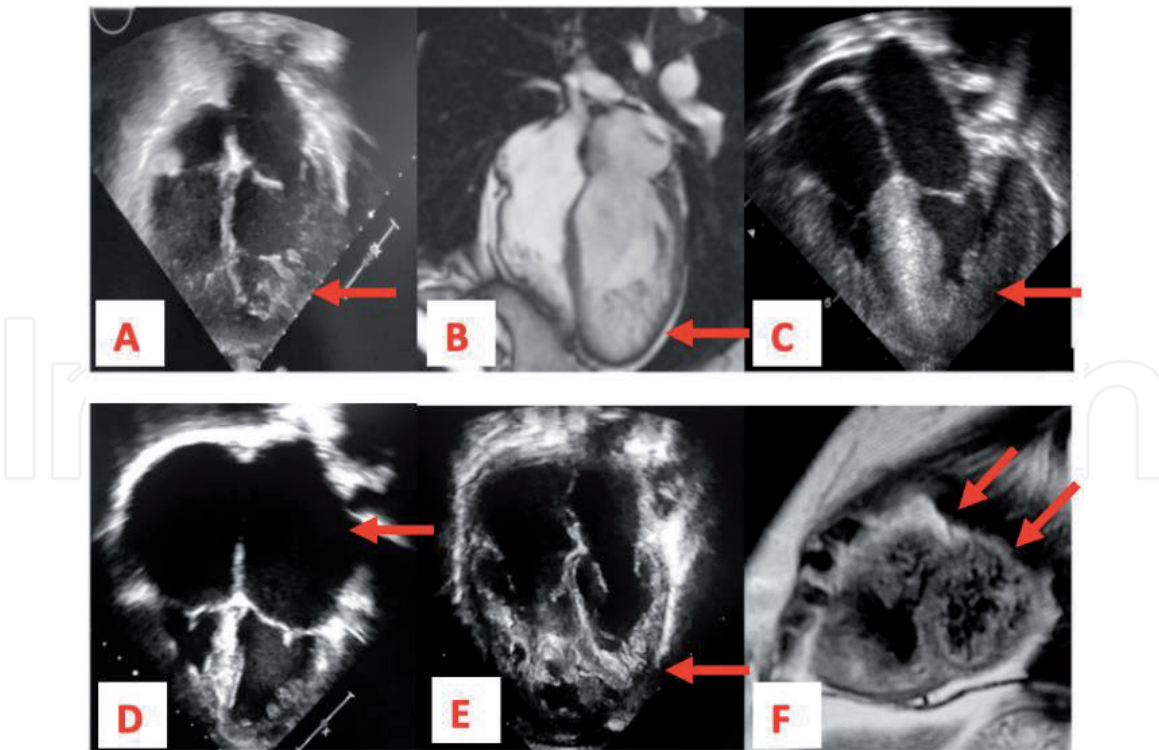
LVNC phenotypes. (A) Echocardiographic 4-chamber view displays the benign type of LVNC characterized by the cardinal feature of left ventricular trabeculations (arrow) with normal anatomy and function; (B) cardiac magnetic resonance (cMRI) 4-chamber view displays the dilated type of LVNC, notice the enlargement of the LV and the presence of apical and lateral trabeculations (arrow); (C) echocardiographic 4-chamber view shows the hypertrophic type of LVNC represented by asymmetric hypertrophy of the interventricular septum and the presence of lateral LV trabeculations (arrow); (D) echocardiography displaying the restrictive type of LVNC, notice the significant bilateral atrial enlargement (arrows) and the left ventricular dysfunction showing spontaneous cavitory contrast; (E) echocardiography shows features suggestive of bilateral ventricular hypertrabeculations (arrows); (F) cMRI in a short axis view displays a mixed LVNC phenotype represented by dilated and dysfunctional ventricles in a patient with ventricular arrhythmias and biventricular trabeculations (arrows).
